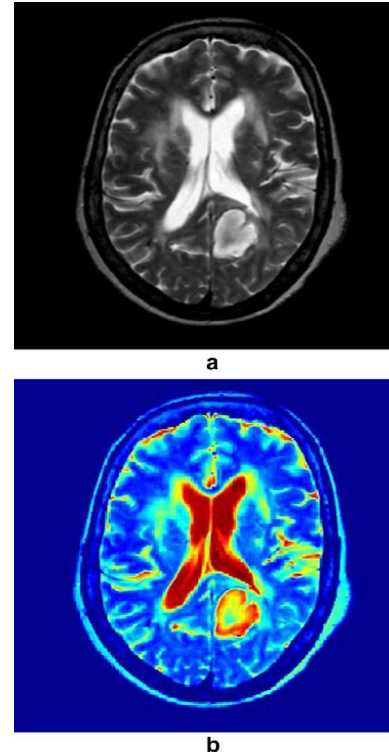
Original MRI T1-weighted brain images, (a) gray-level image and (b) color image
